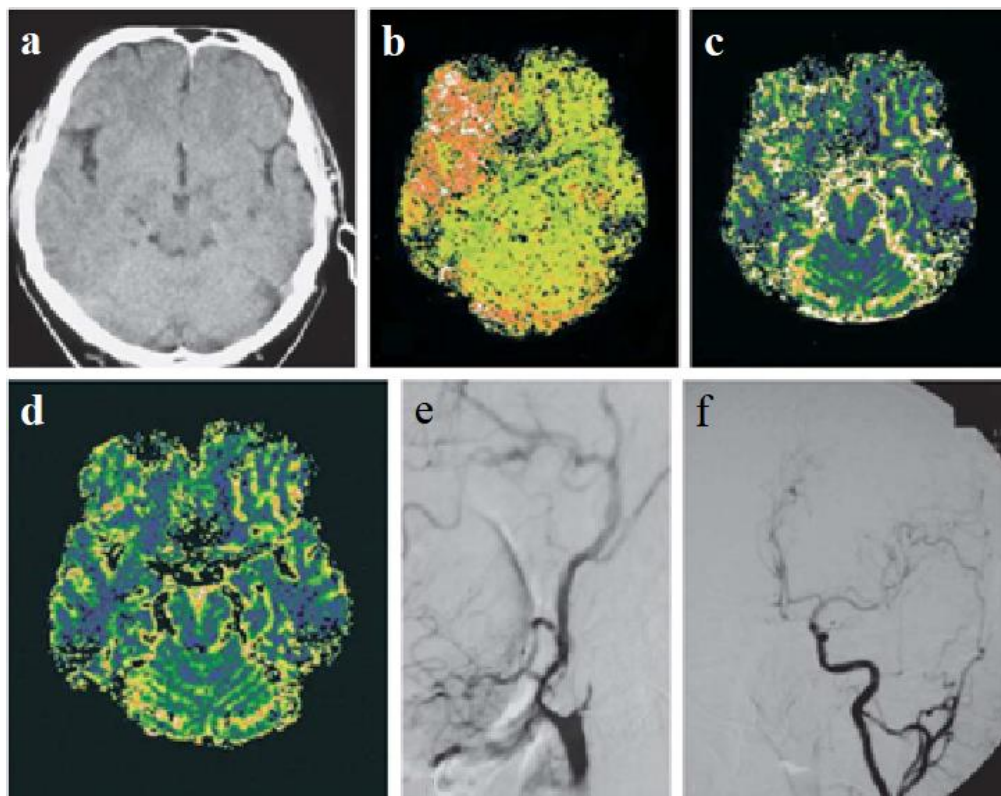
a) A CT scan of a 63-year-old patient with a left-sided hemiparesis revealed no abnormalities. (b) Perfusion-weighted CT showed a perfusion deficit in the mean transit time parameter maps as well as on (c) the regional cerebral blood volume map and on (d) the regional cerebral blood flow map. Digital subtraction angiography (e and f) on the right-hand side shows occlusion of the internal carotid artery (Marincek and Dondelinger, 2007).
